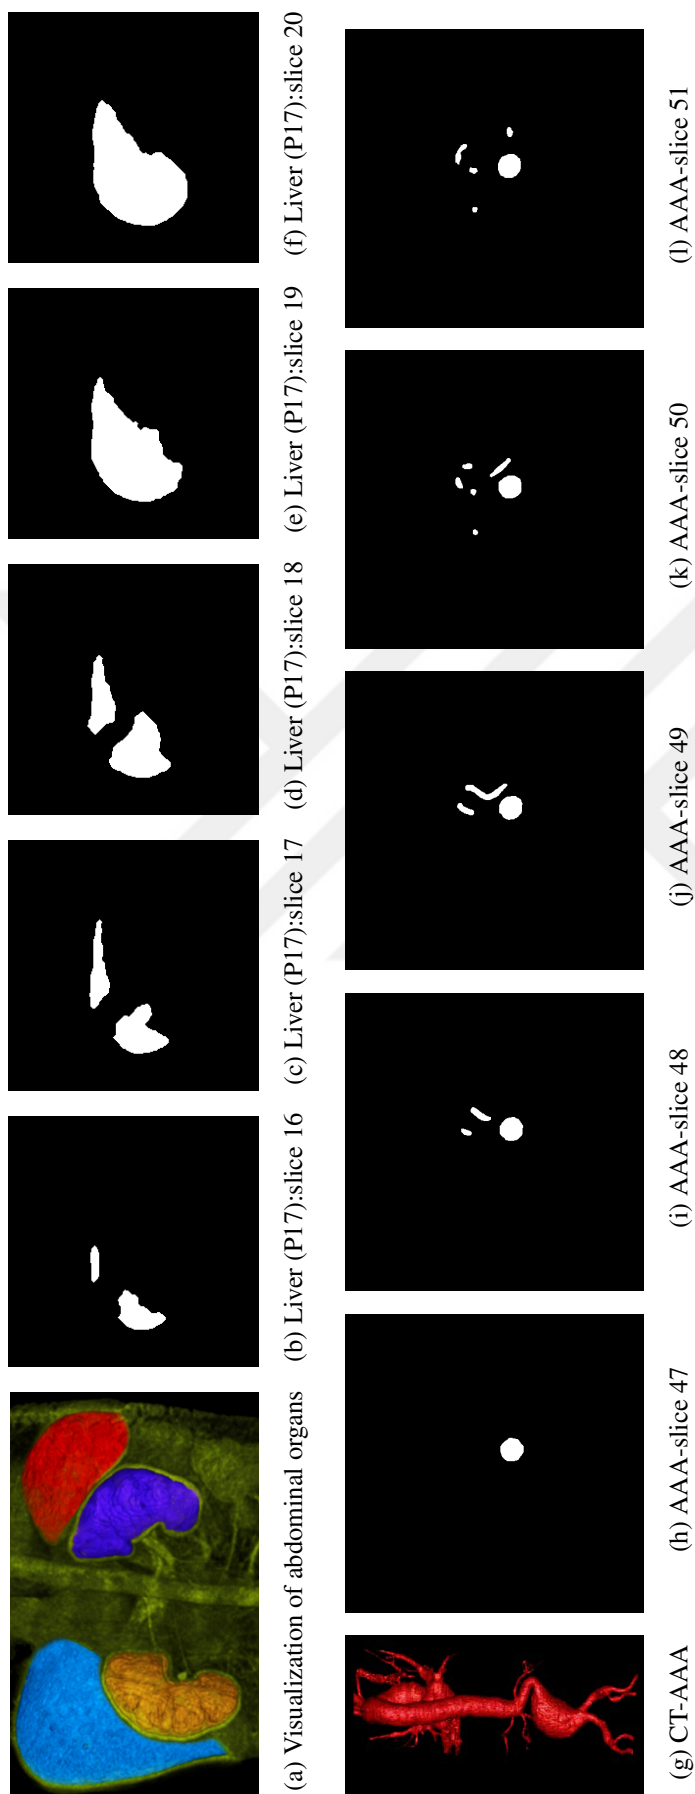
Images data set: (b)-(f) T1 weighted segmented bi-level MR sequence (h)-(l) abdominal aortic aneurysms aortic (AAA) tree (CT-Angiography)
